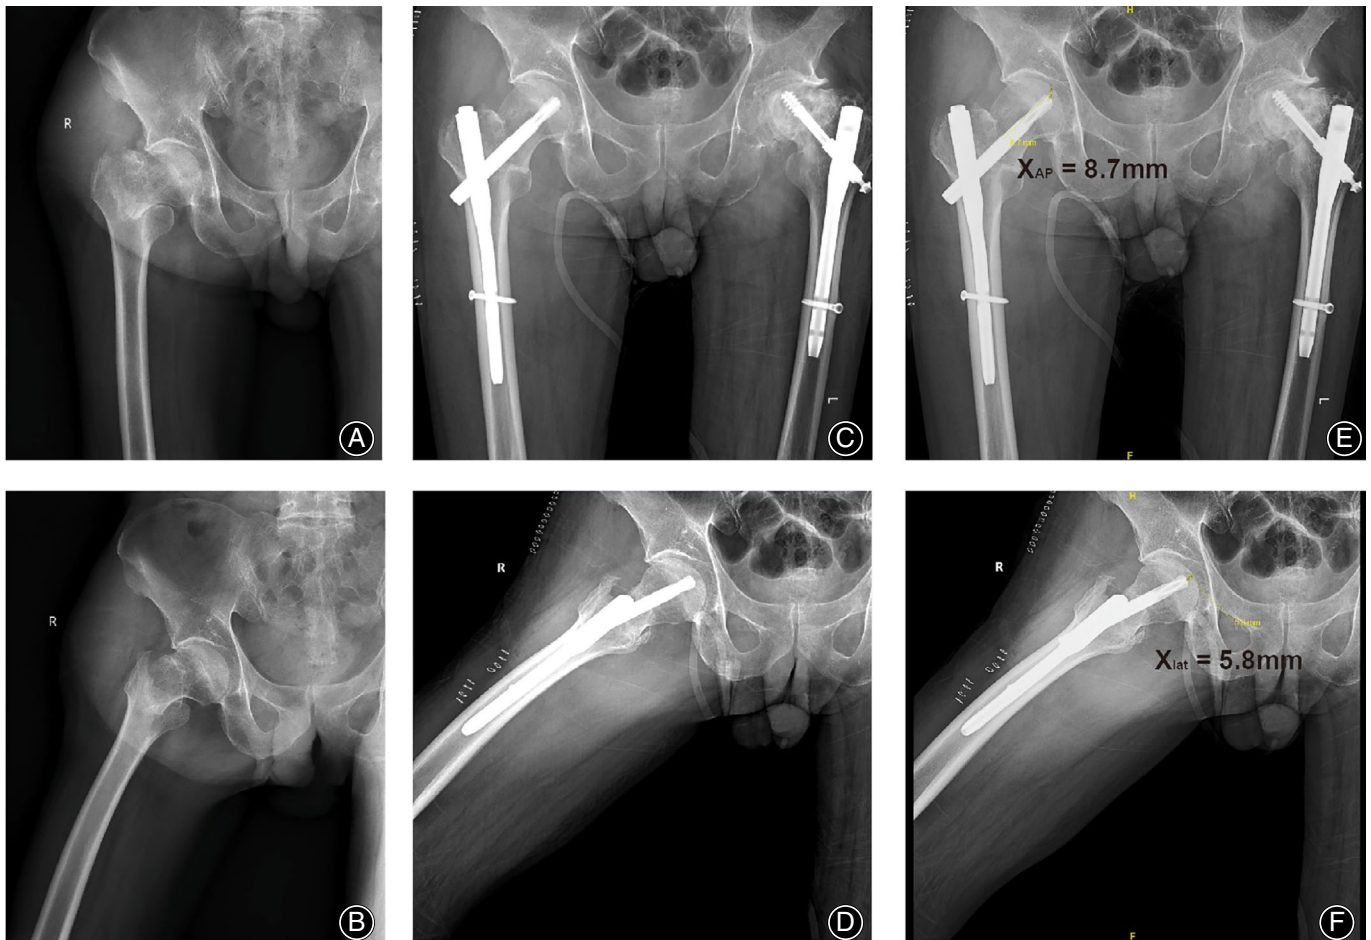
Radiographs before and after the first operation. (A, B): preoperative lateral and anteroposterior X-ray of the right hip joint shows right femoral intertrochanteric fracture; (C, D): lateral and anteroposterior X-ray after closed reduction and internal fixation with PFNA-II; (E, F): the tip-apex distance (TAD) in AP (8.7 mm) and lateral (5.8 mm) view after the first operation, and final TAD is addition of both the values (14.5 mm)
